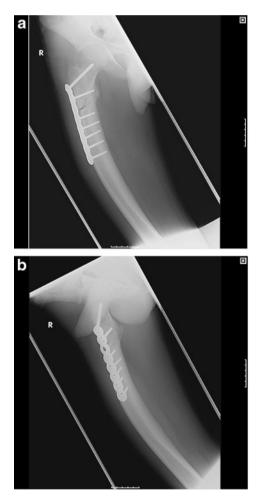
a, b AP and lateral post-operative radiograph of the right figure showing operative stabilisation of the fracture
